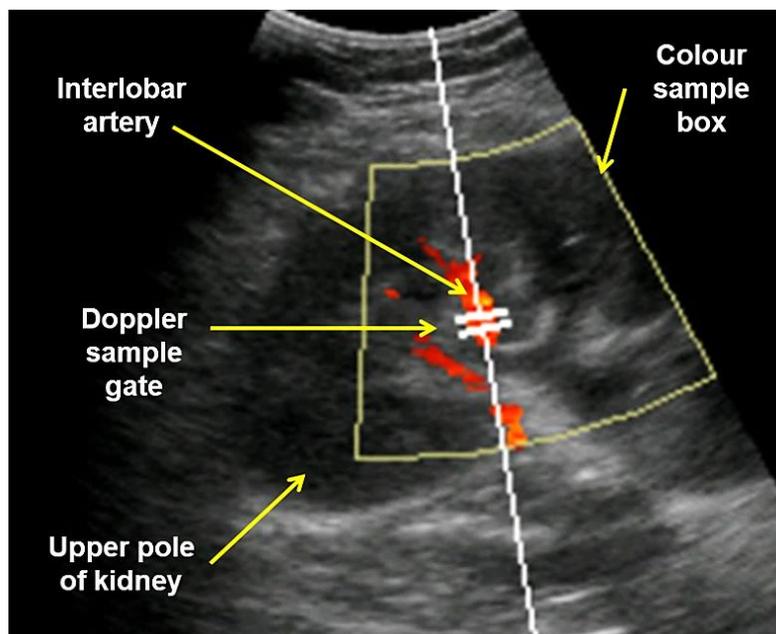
Spectral Doppler sample gate is placed over the lumen of the target vessel. Transducer is positioned to align the sample beam and vessel to eliminate need for angle correction.
